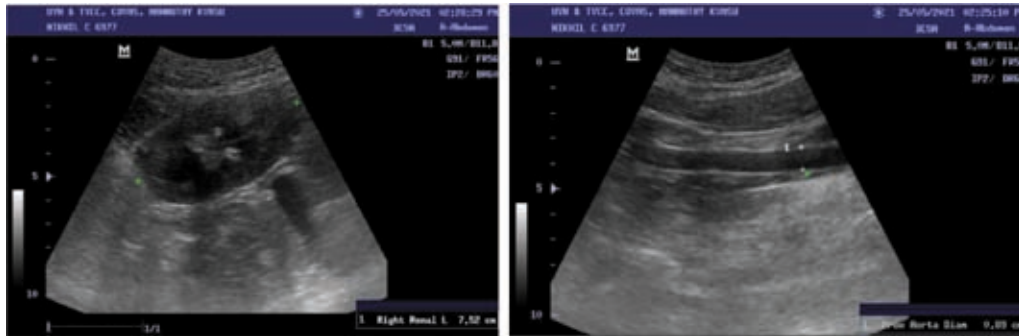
Ultrasound image showing measurement of kidney size by measuring kidney length (between cursors) and aorta diameter (right) to obtain a ratio.
